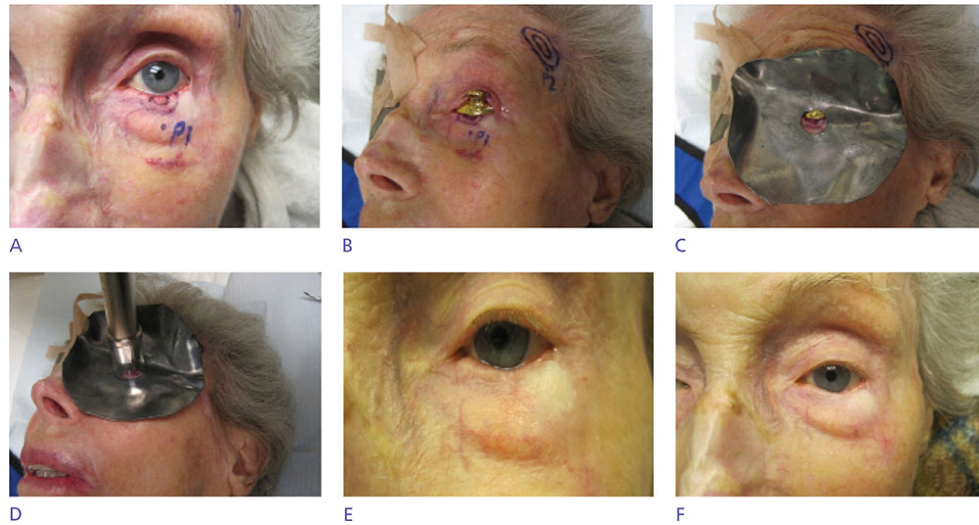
Treatment of an in situ large squamous cell carcinoma of the eyelid with superficial radiation. The patient was a 93-year-old woman with a history of numerous difficult skin cancers on her face for which she had undergone multiple Mohs surgeries and skin grafts and flaps. She presented with a crusted lesion on her left lower eyelid. The lesion is near (medial) to a Mohs site repaired with a full-thickness skin graft for squamous cell carcinoma in situ 2 years earlier. This lesion was biopsied and found to be an actinic keratosis/squamous cell carcinoma in situ. Since the patient had undergone Mohs surgery of the left lower eyelid with full-thickness skin graft 2 years prior, Mohs surgery on this lesion could potentially worsen her existing slight ectropion. After discussing the use of Mohs surgery or SRT to treat this lesion, the patient chose SRT. The clinical lesion was identified and circled and a 5-mm border was drawn around this. A 0.762-mm-thick lead shield was custom made to include a 1.3-cm field and placed over the lesion and extended field. The patient was placed on the x-ray table in the supine position. One drop of tetracaine solution was instilled into her left eye and after 2 minutes, a lubricated gold-plated lead shield was placed inside the eyelid of the left eye. This was covered with the custom lead shield, while the right eye was covered with a standard lead eye shield and the thyroid was also covered with a lead shield. Using a 1.5-cm cone, seven fractions of 498.6 cGy (3490.2 cGy total) were delivered at 50 kV and 10 mA with a $D_{1/2}$ of 5.8 mm over a 3-week period which yields a TDF of 92. The patient tolerated SRT well and without complaints during the treatment regimen. She has no complaints of dry eye, or more than her usual amount of eye weeping. (A) The lesion was identified and circled, and a 5-mm border was drawn around this. (B) Two minutes after tetracaine solution was instilled into the left eye, a lubricated gold-plated lead shield was placed inside the eyelid of the left eye. (C) A custom 0.762-mm-thick lead shield was custom made to include a 1.3-cm field and placed over the lesion and extended field. (D) Using a 1.5-cm cone, seven fractions of 498.6 cGy (3490.2 cGy total) were delivered at 50 kV and 10 mA with a $D_{1/2}$ of 5.8 mm over a 3-week period which yields a TDF of 92. (E) Appearance of the eyelid 72 days posttreatment. (F) There was no recurrence after 15 months.
